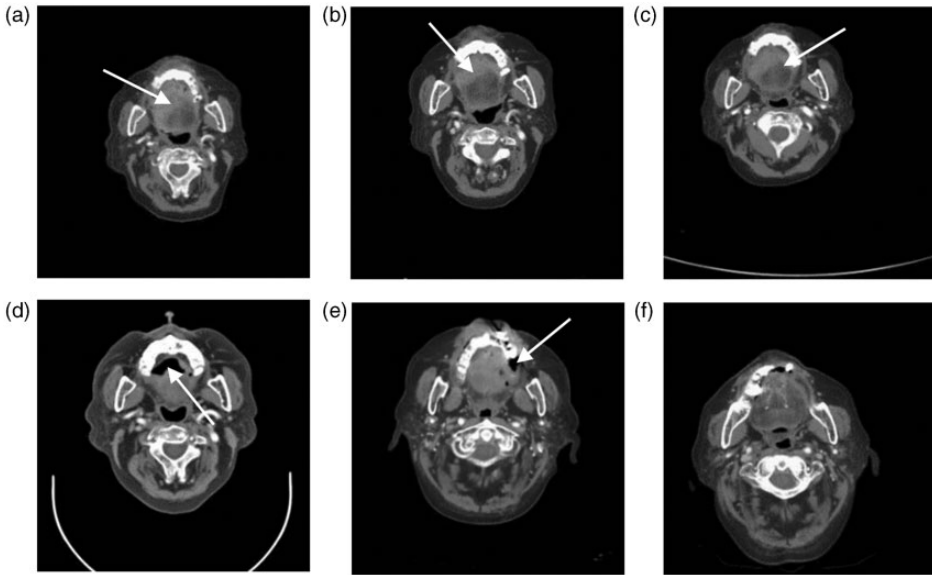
Preoperative and postoperative enhanced computed tomography (CT) images of a 56-year-old male patient that presented with a skin mass on his lip showing that the tumour volume significantly reduced postoperatively. The sequence of images shows the tumour before and then after each operation: (a) CT image of the tumour (arrow) before treatment; (b) the tumour (arrow) slightly widened following a single round of therapy; (c) the extent of the tumour (arrow) was less than it was following the previous therapy; (d) tumour tissue necrosis (arrow) due to embolization; (e) shrinkage of the necrotic cavity (arrow) within the tumour and (f) no necrotic cavity is present.
